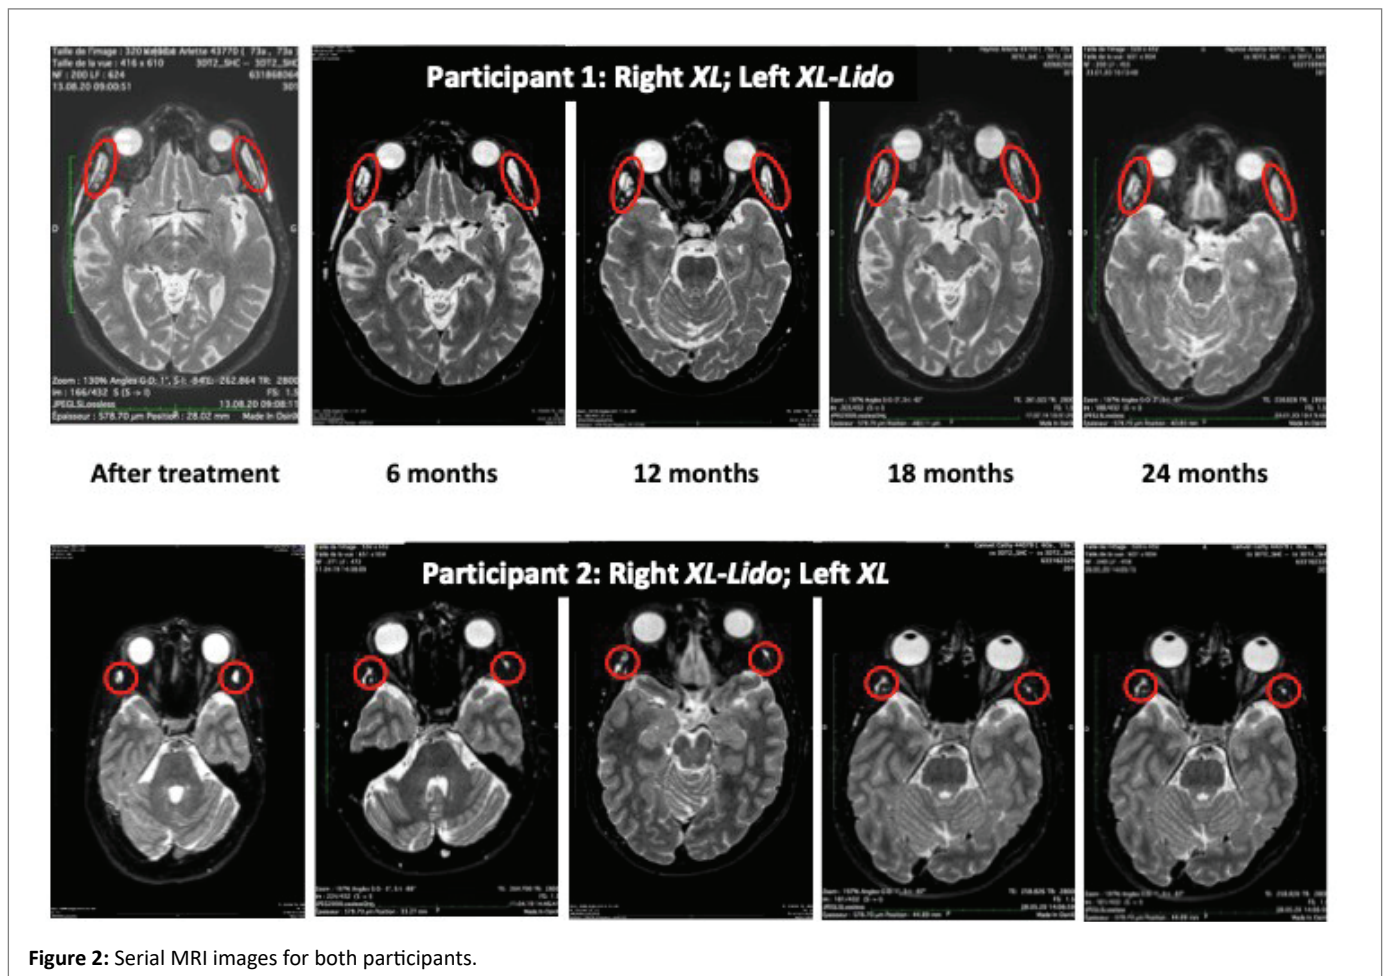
Serial MRI images for both participants.
